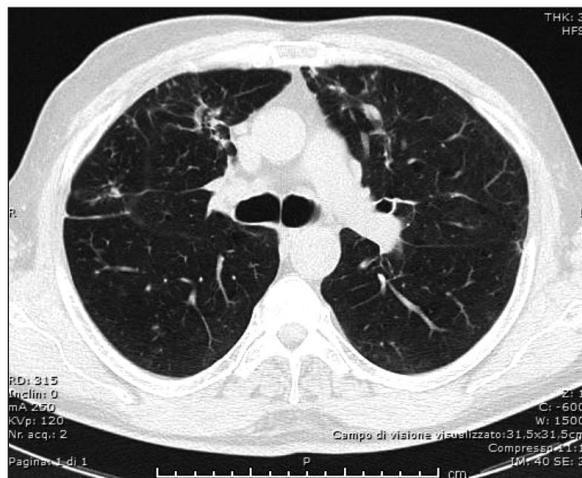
Thoracic CT at four-month follow-up.
